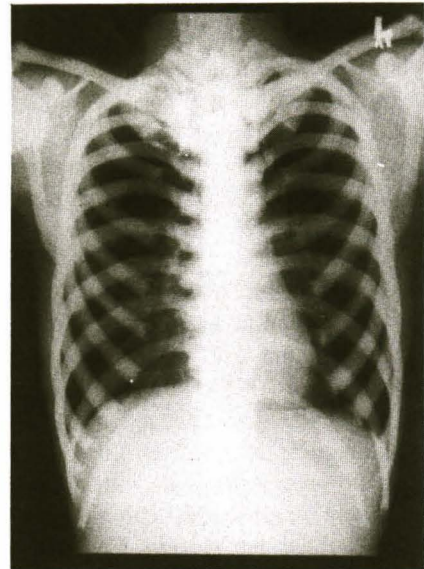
Chest X-ray from case 2 demonstrating the typical radiologic appearance of osteopetrosis. Note the marbling of the bone and the dense bone formation.
